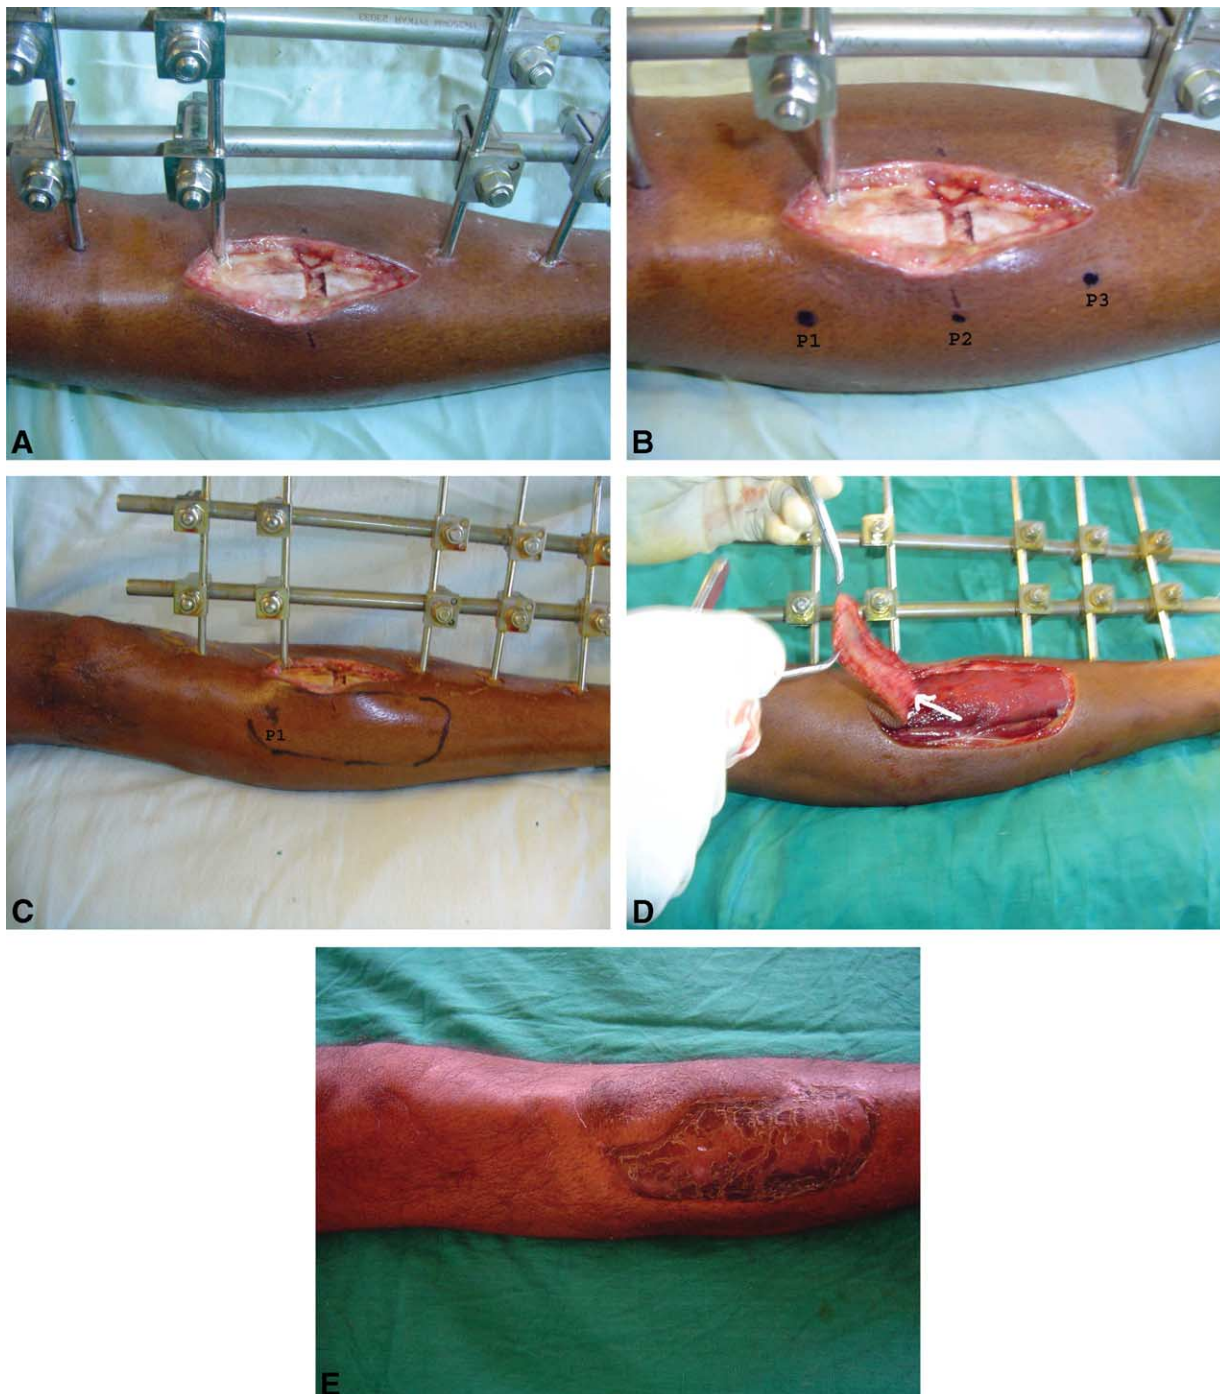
(Case 3) (A) Post-traumatic pretibial wound measuring 4×5 cm exposing the fracture site in middle 1/3 of the tibia. (B) Pre-operative three perforators were identified using a hand; held Doppler [P1, P2, P3]. (C) The proximal perforator [P1] was more suitable in this case, hence was chosen. (D) Flap raised till the perforator visualised [white arrow]. (E) Well settled flap after 6 weeks.
